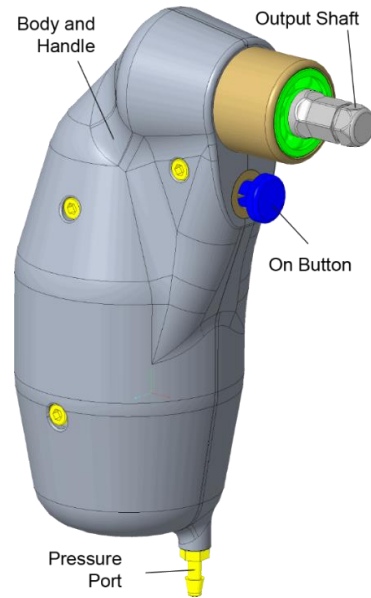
Pneumatic drill built by Johns Hopkins. The drill connects to the standard room air supply through the pressure port at the bottom. It is completely safe in the MRI environment as it is constructed of plastic, ceramic, and rubber materials. It is the same size as the commercial drill and uses the same drills.
